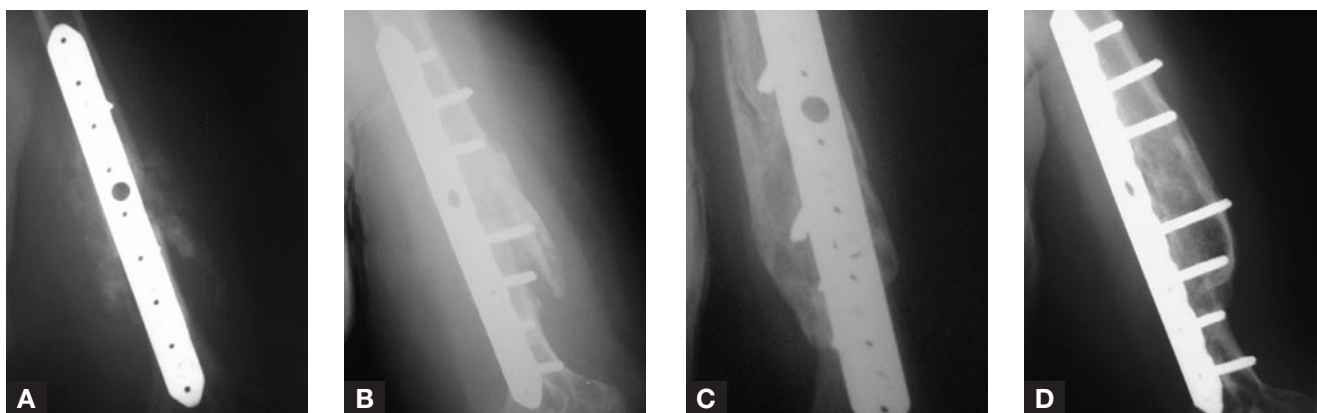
Sixty-nine-year-old woman with nonunion after failed intramedullary nail for failed functional brace treatment. (A,B) Immediate postoperative radiographs show locking plate and graft. (C,D) Follow-up radiographs show abundant bony union.
